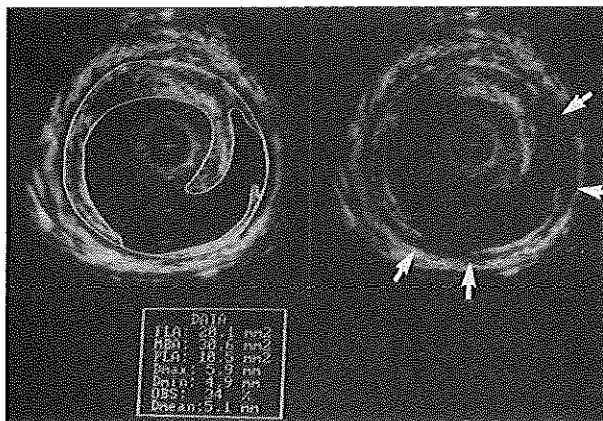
Intravascular ultrasound (IVUS) cross-sections obtained after balloon angioplasty showing media rupture and dissection. Left panel: The IVUS cross-section is contour traced off-line facilitating recognition and measurement of lumen area (FLA), media-bounded area (MBA) and plaque area (PLA). Right panel: White arrows indicate the sections of media rupture. + = catheter; calibration = 1 mm.
